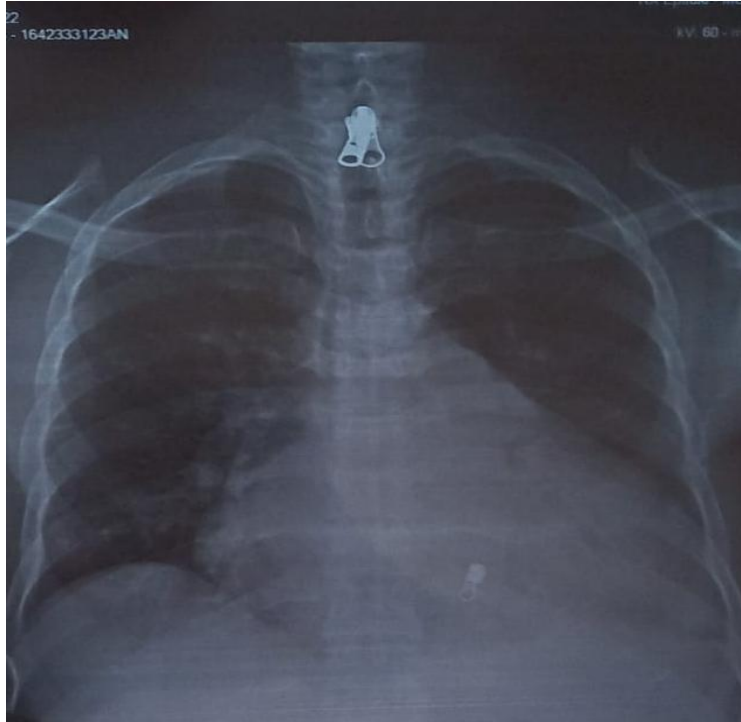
Frontal chest X-ray: Cardiomegaly with ventricular hypertrophy associated with obliteration of the bottom of the left costo-diaphragmatic sac.
